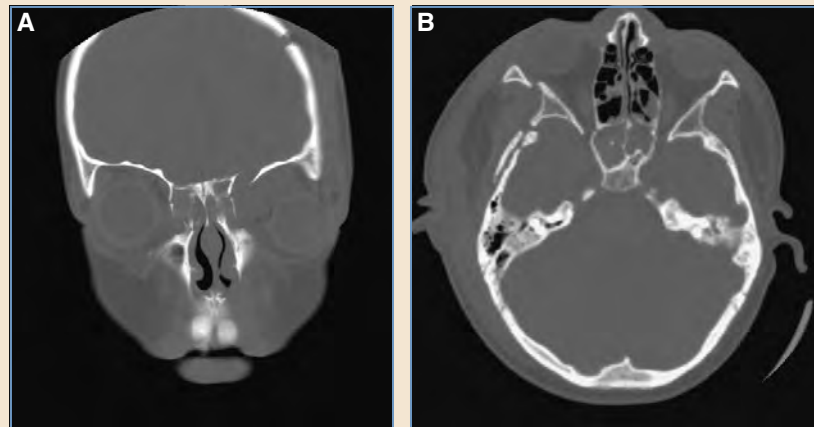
A, Coronal CT scan showing a left-sided oblique craniofacial fracture pattern. B, Axial CT scan showing a right-sided oblique craniofacial fracture pattern.
